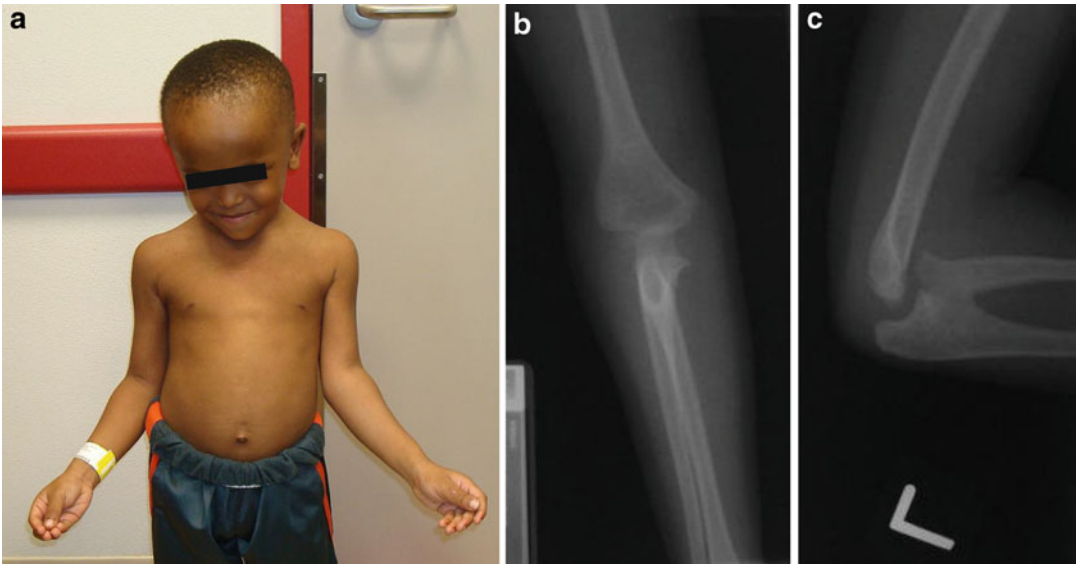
(a–c) This 3½-year-old boy was evaluated for familial bilateral proximal radioulnar synostosis (shown by radiograph) (b, c). He had a large head, frontal bossing, and depressed nasal bridge is and unable to supinate both wrists (a)
